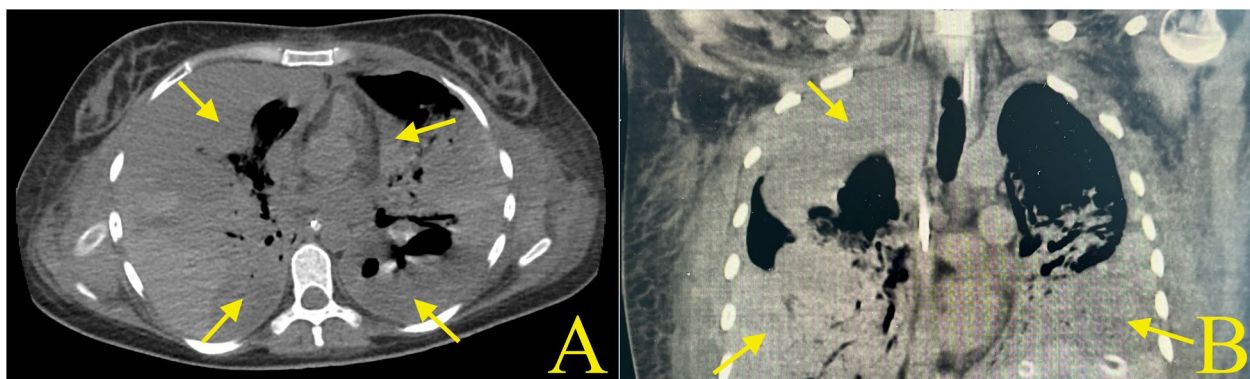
Computed tomography scans of transverse (A) and frontal (B) sections clearly shows bulky clots in both pleural cavities. They are 56 mm on the right and 42 mm on the left. Both lung wings are largely airless except for the upper lobes. The mediastinum is compressed by hematomas (arrows)
